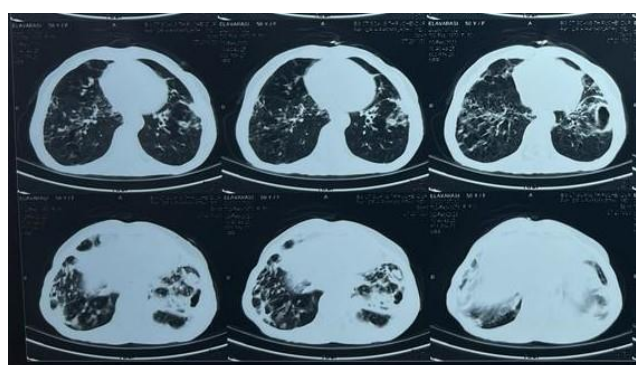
HRCT thorax showing consolidation in bilateral lower lobes
